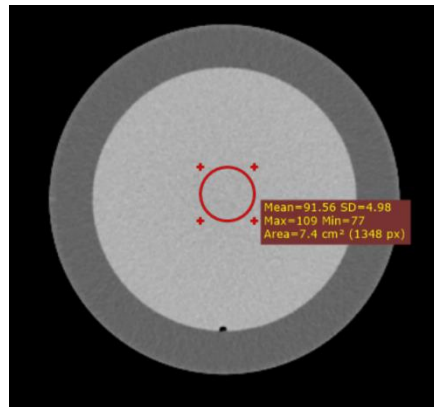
Measurement of noise in CT image
